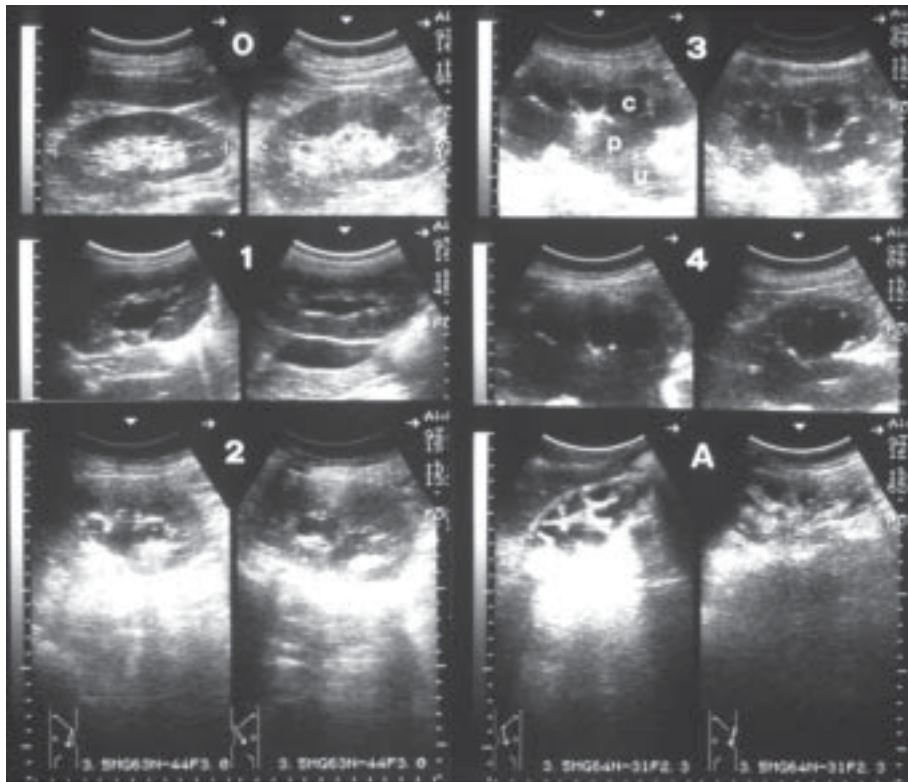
Renal sonograms showing normal (0) to grade I-IV hydronephrosis, and atrophied kidneys (A).
